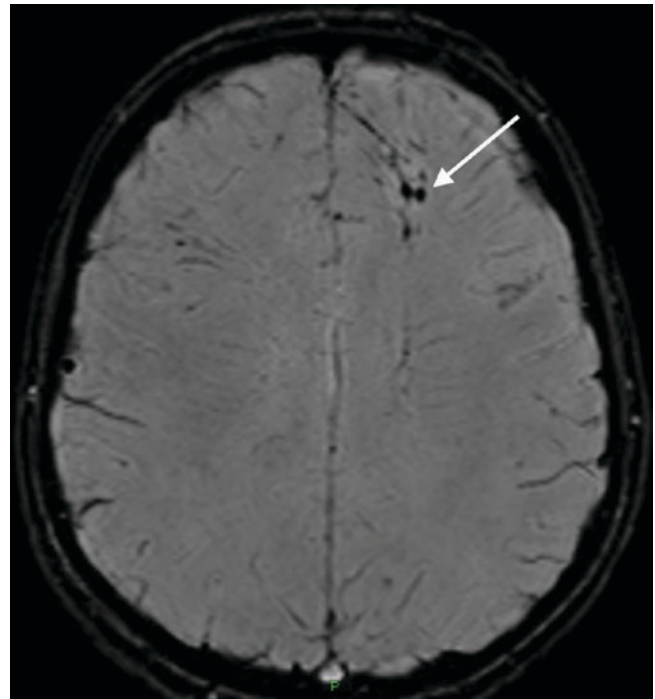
DAI. Axial susceptibility-weighted MR image, which is sensitive for blood products, demonstrates tiny foci of low signal intensity (arrow) in the left frontal lobe, in keeping with tiny haemorrhages
